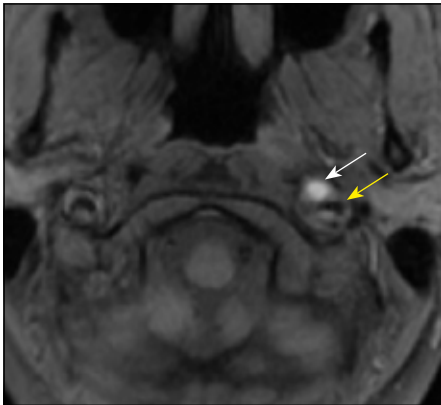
Gradient echo magnetic resonance image (axial section) showing haematoma in the wall of dissected left internal carotid artery (white arrow). Yellow arrow shows narrowed lumen of the dissected artery.
